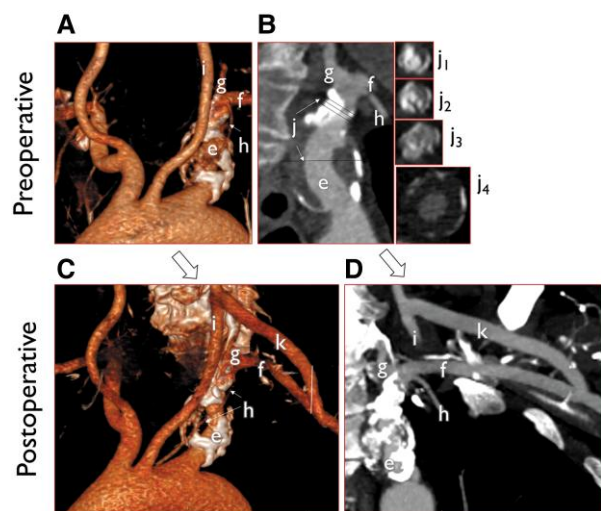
Computed tomography angiography; preoperative (A and B) and postoperative (C and D) 3D reconstructions (A and C) and key CT (B and D) images of the subclavian aneurysm and surrounding vascular structures. Bypass graft (k) is open and functioning in the postoperative images (C and D). e: subclavian aneurysm, f: distal subclavian artery, g: left vertebral artery, h: left internal mammary artery-LAD graft, i: left carotid artery, j: cross-sections of the aneurysm (1–4; superior to inferior slice), and k: carotid-subclavian bypass graft.
